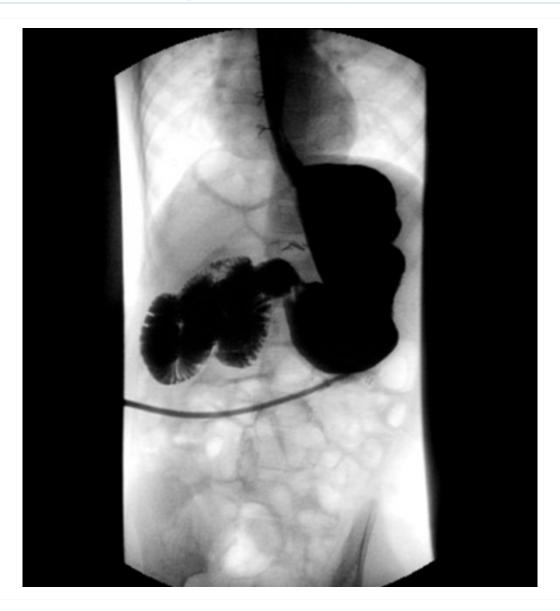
Abdominal x-ray showing intestinal malrotation; note the small bowel is located to the right side of the midline
